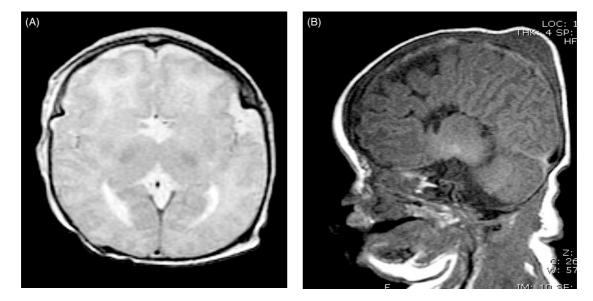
MRI of the brain in newborn patient 2. Axial (A) FSE T2-weighted and sagittal (B) T1 spin echo MR images show characteristic finding of agenesis of the *corpus callosum* with colpocephaly and absence of the cingulate gyrus. The head, and brachycephalicy
